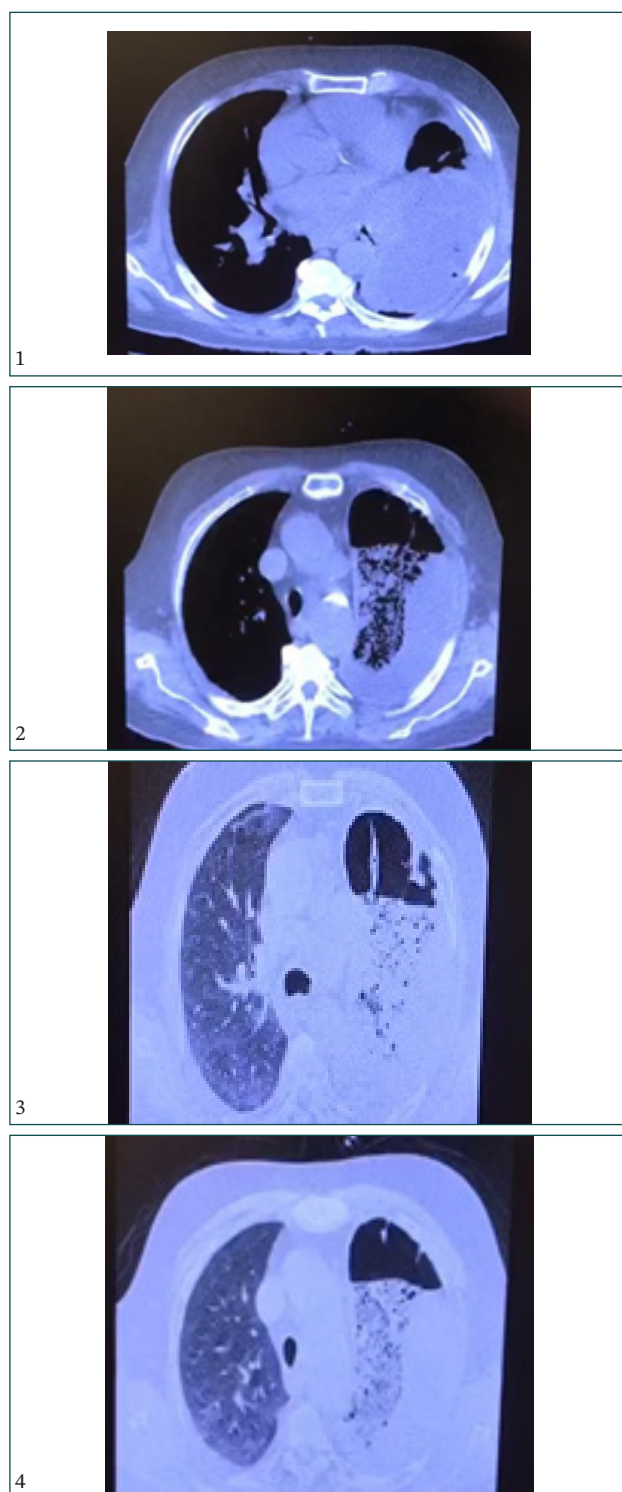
Mediastinal view (1&2) and Parenchymal view (3&4) in Lung CT Scan which show Necrotic mass in the upper lobe of the left lung with endobronchial involvement
